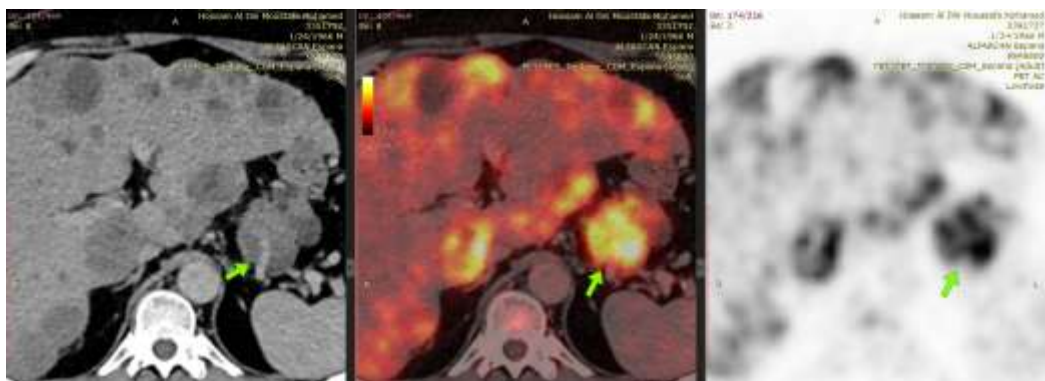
CT with contrast, fused images and PET axial cuts demonstrates FDG-avid irregular exophytic pancreatic body mass. The mass invades the adjacent splenic artery
